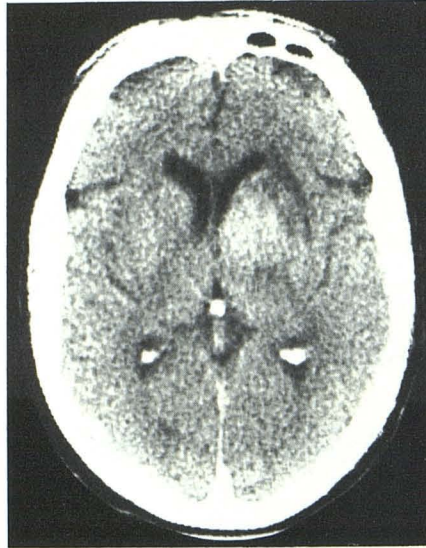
Lesion of third ventricle in 29-year-old man. A and B, Contrast-enhanced CT scans. Appearance similar to colloid cyst (arrows). C, Prolonged T2 relaxation time equal to that of CSF on MR imaging (arrow). Lesion cannot be demarcated from fluid in third ventricle. Second lesion in inferior vermis deformed fourth ventricle on CT (D, arrow) and CSF demonstrated T2 relaxation time equal to CSF of fourth ventricle (E, arrow). Lesion also could not be demarcated from adjacent CSF by MR.
